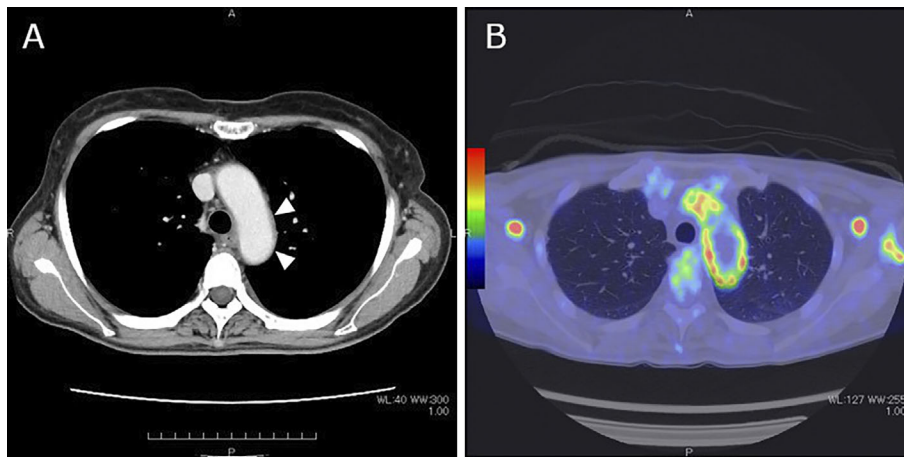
(A) Contrast-enhanced computed tomography showing slight thickening of the aortic wall, which was non-contributory (arrowheads). (B) Positron emission tomography-computed tomography showing an intense fluorodeoxyglucose uptake in the corresponding aortic lesion.
